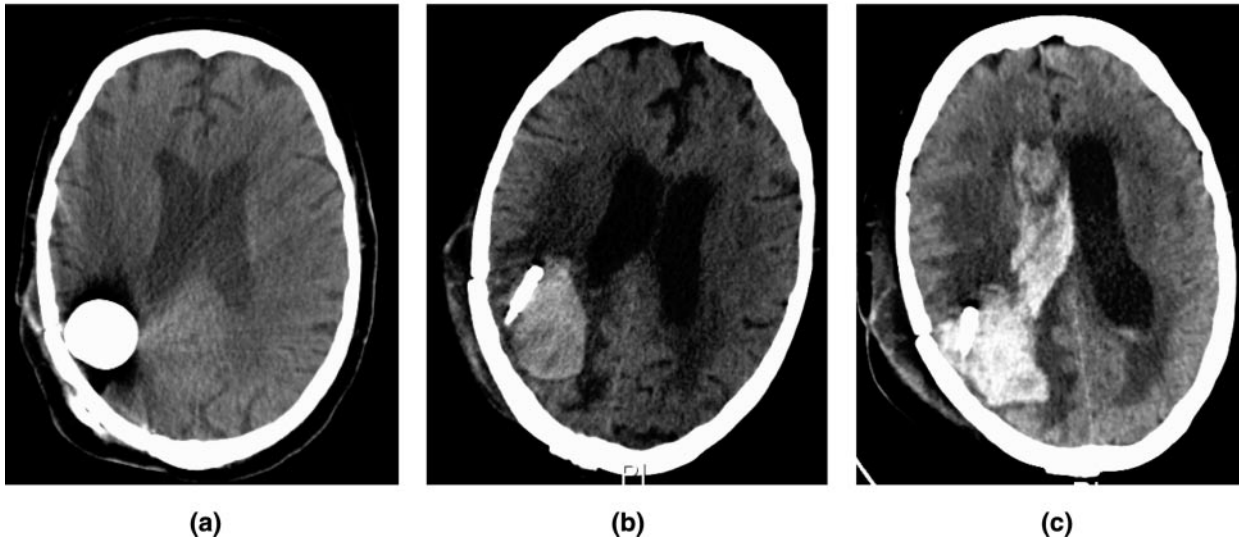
Non-contrast head CT scans performed during hospitalization. (a) The Gliasite planning CT (Hospital Day 1) shows no hemorrhage. (b) Approximately 8 hours after Iotrex removal from the Gliasite RTS (Hospital Day 5), there is a  $4.7 \times 3.2$  cm right parietal intracavitary hematoma outside the confines of the Gliasite balloon. (c) Approximately 13 hours after Iotrex removal from Gliasite RTS (Hospital Day 6), the right parietal hematoma has increased in size to  $5.6 \times 3.6$  cm and dissected into the right ventricular system.
